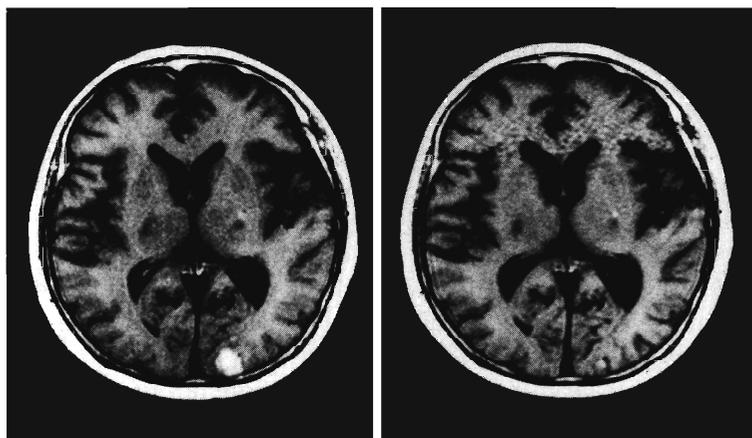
(Left) Contrast-enhanced MRI before chemotherapy reveals a left occipital tumor. (Right) The tumor had almost completely disappeared after gamma knife therapy.
